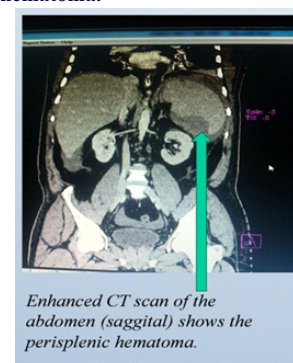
Enhanced CT scan of the abdomen (sagittal) shows the perisplenic hematoma.
